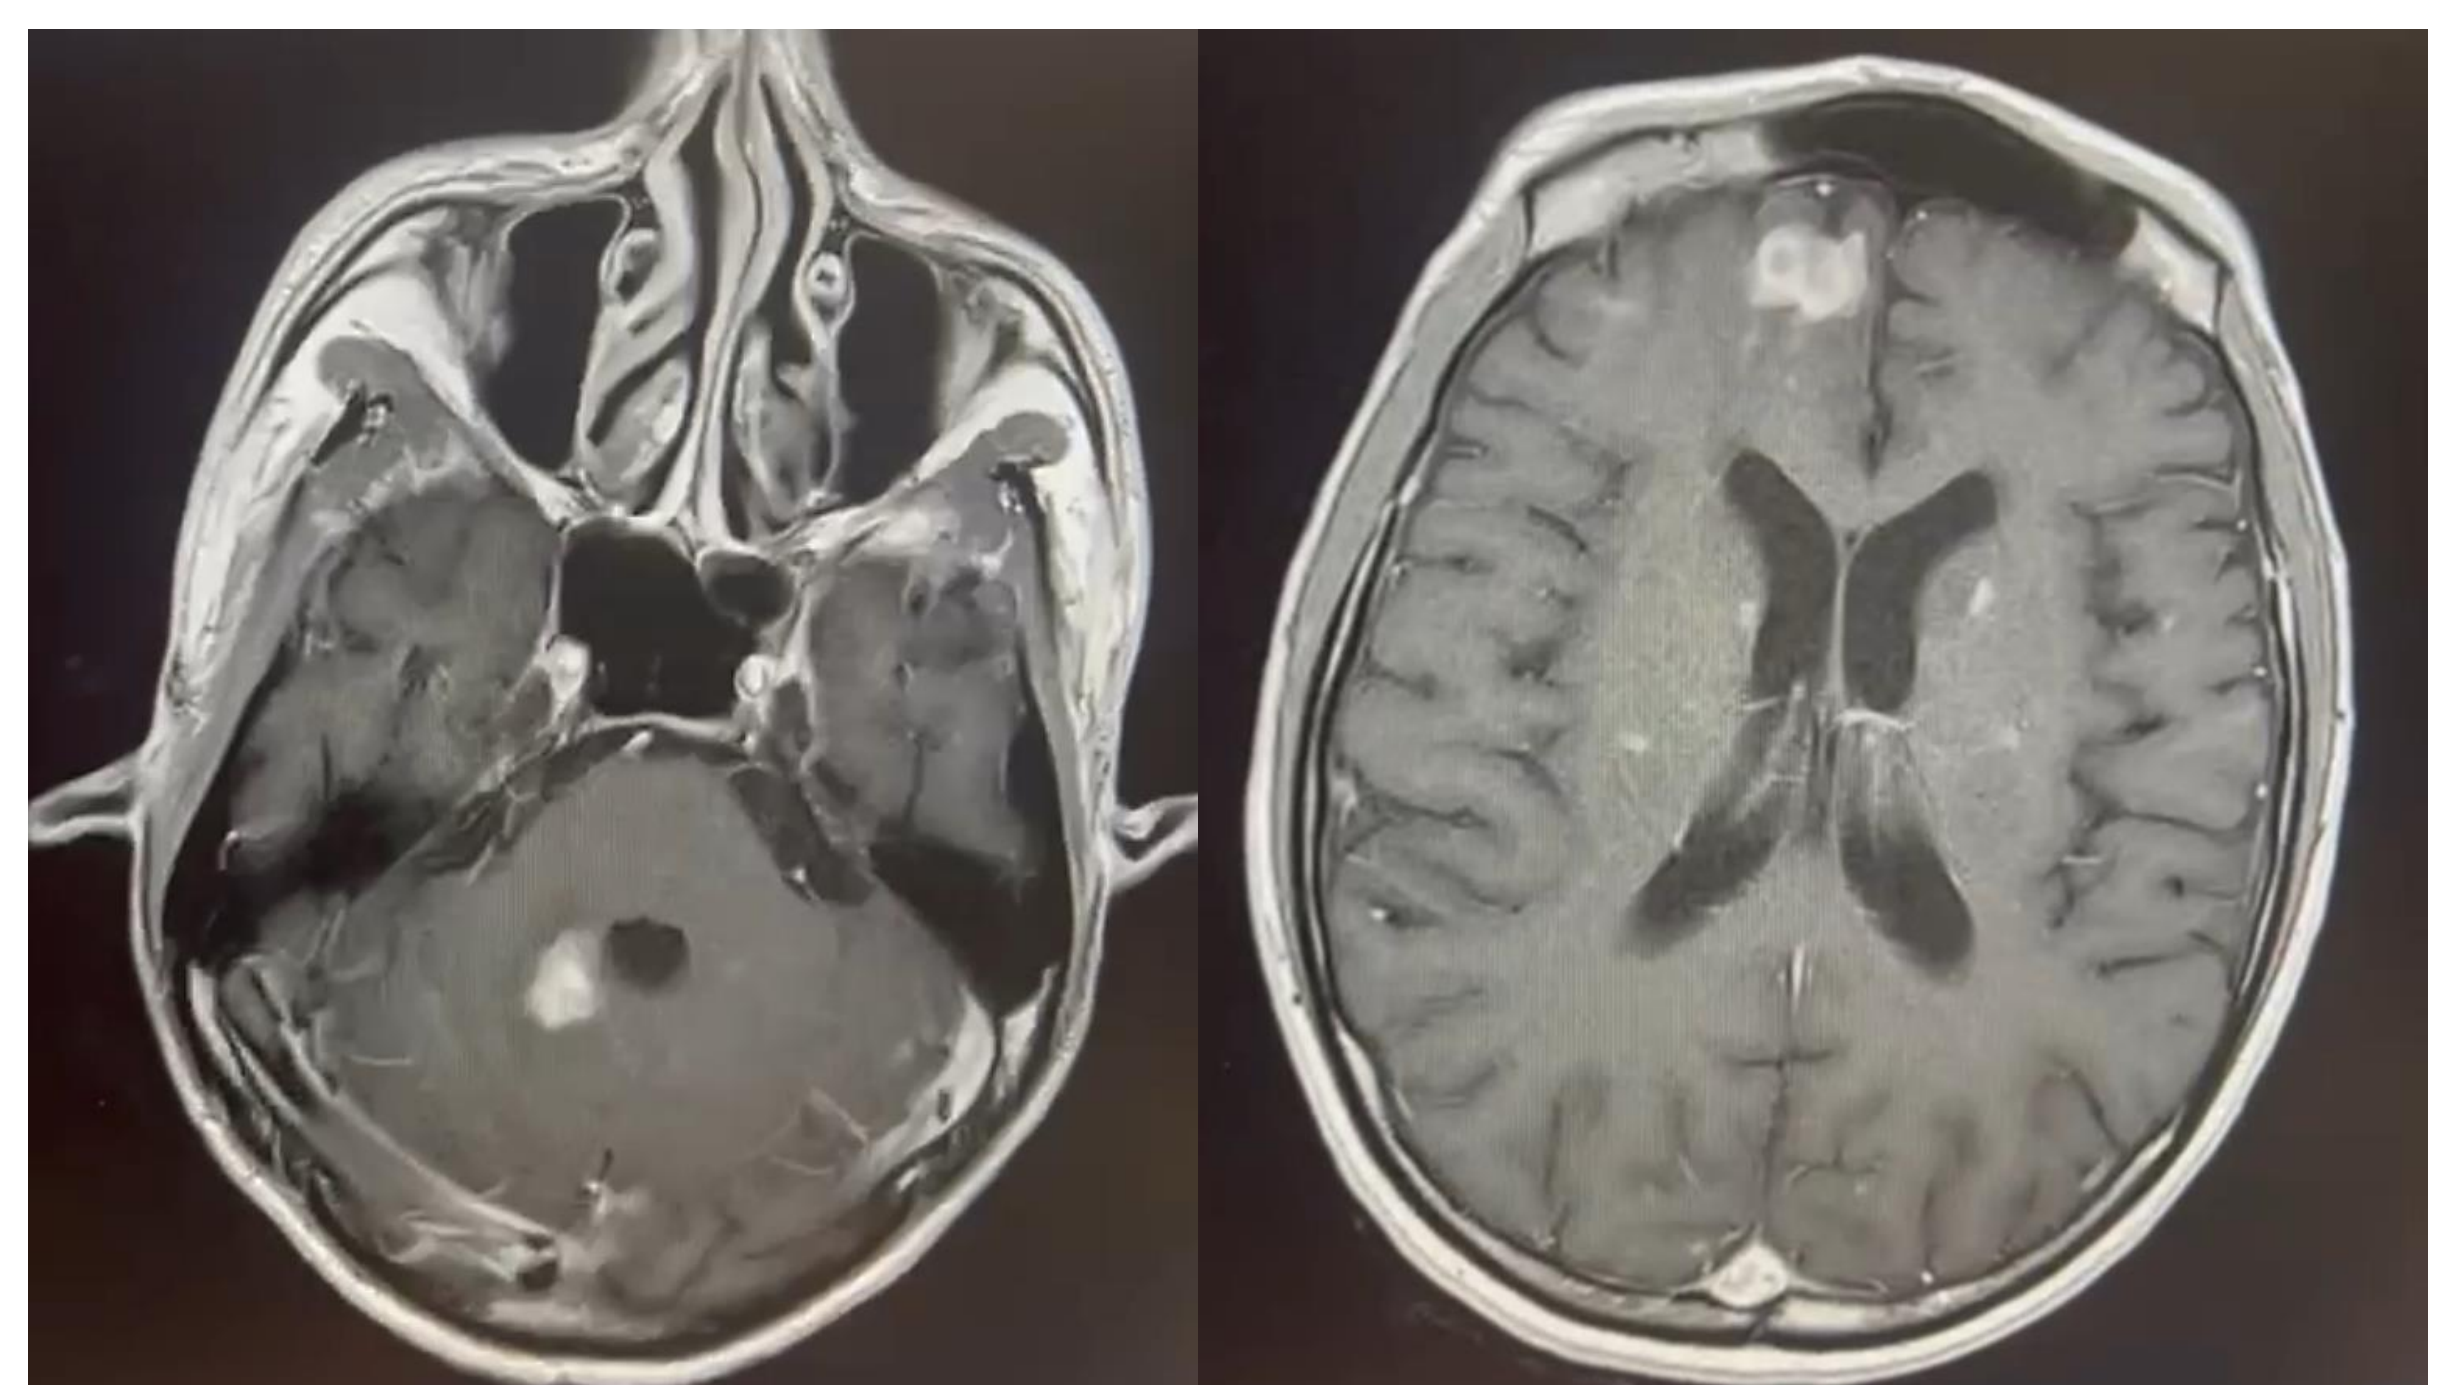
Images from unenhanced MRI head December 2025 showing multiple lesions affecting the frontal, parietal, and temporal lobes.
